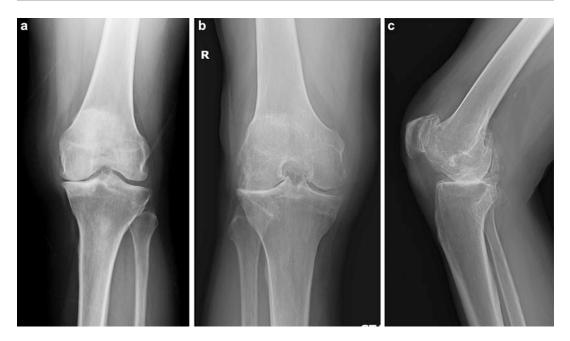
AP radiographs of the knee showing different patterns of wear caused by osteoarthritis. (a) The medial compartment is worn creating a bow-legged or varus deformity of the leg. (b) The lateral compartment is worn
